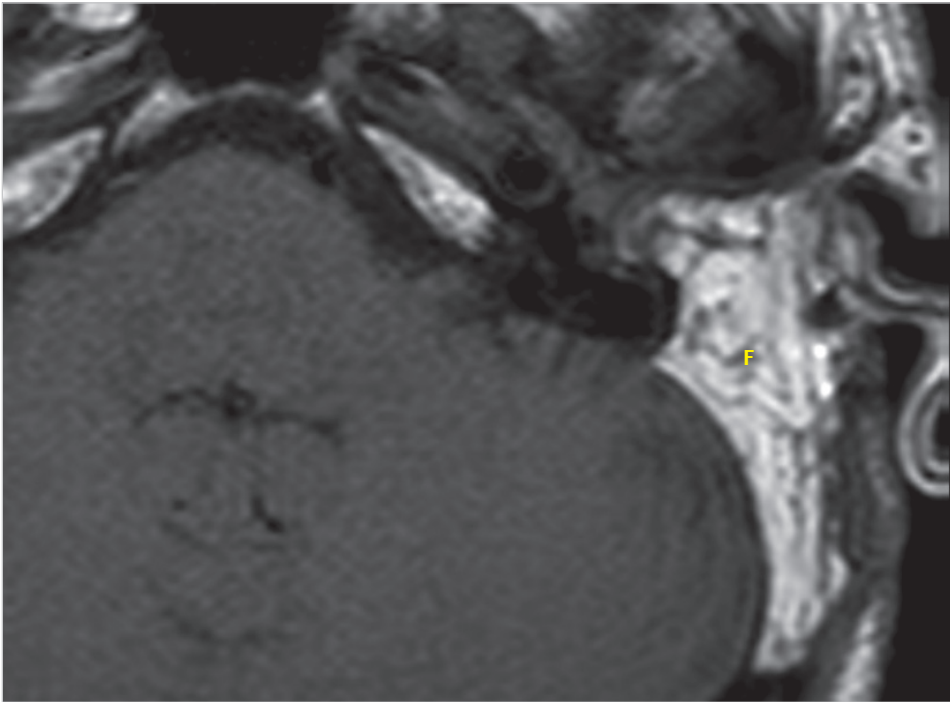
The postoperative MRI shows release of cerebellar compression with appropriate packing of the cavity with abdominal fat. F, abdominal fat.
